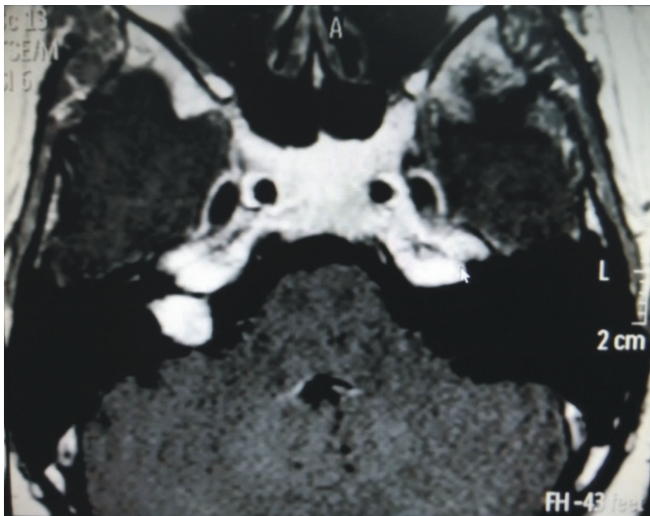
T1 weighted MRI in axial view showed hypointense lesion in the right intracanalicular portion of the internal auditory meatus extending to the cerebellopontine angle (arrow).
